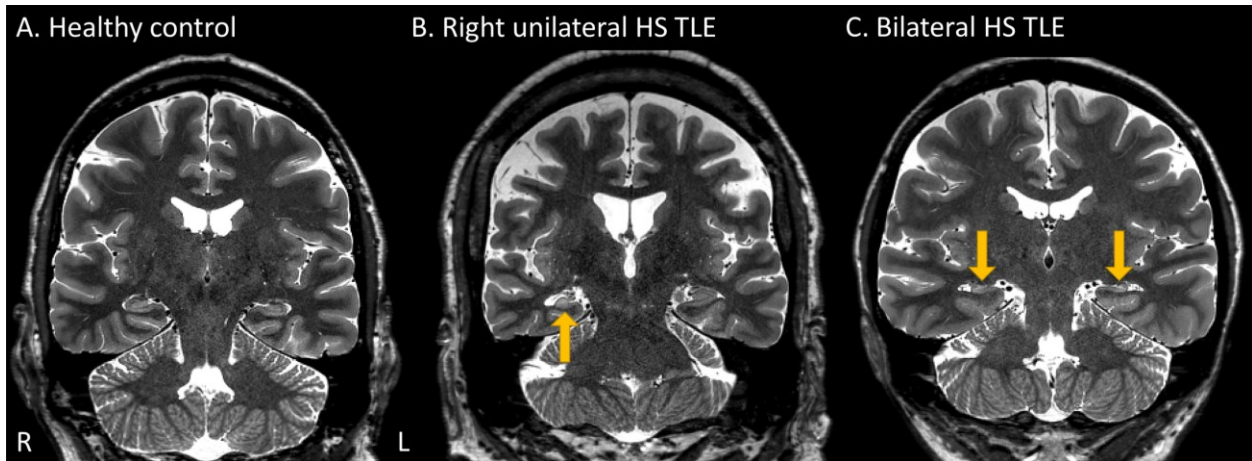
Coronal T2-weighted images of a (A) control (50 years-old male), (B) right unilateral HS (44 years-old male) and (C) bilateral HS patient (59 years-old male). Yellow arrows point to the ipsilateral sclerotic hippocampus with marked atrophy and enhanced T2-weighted signal.
